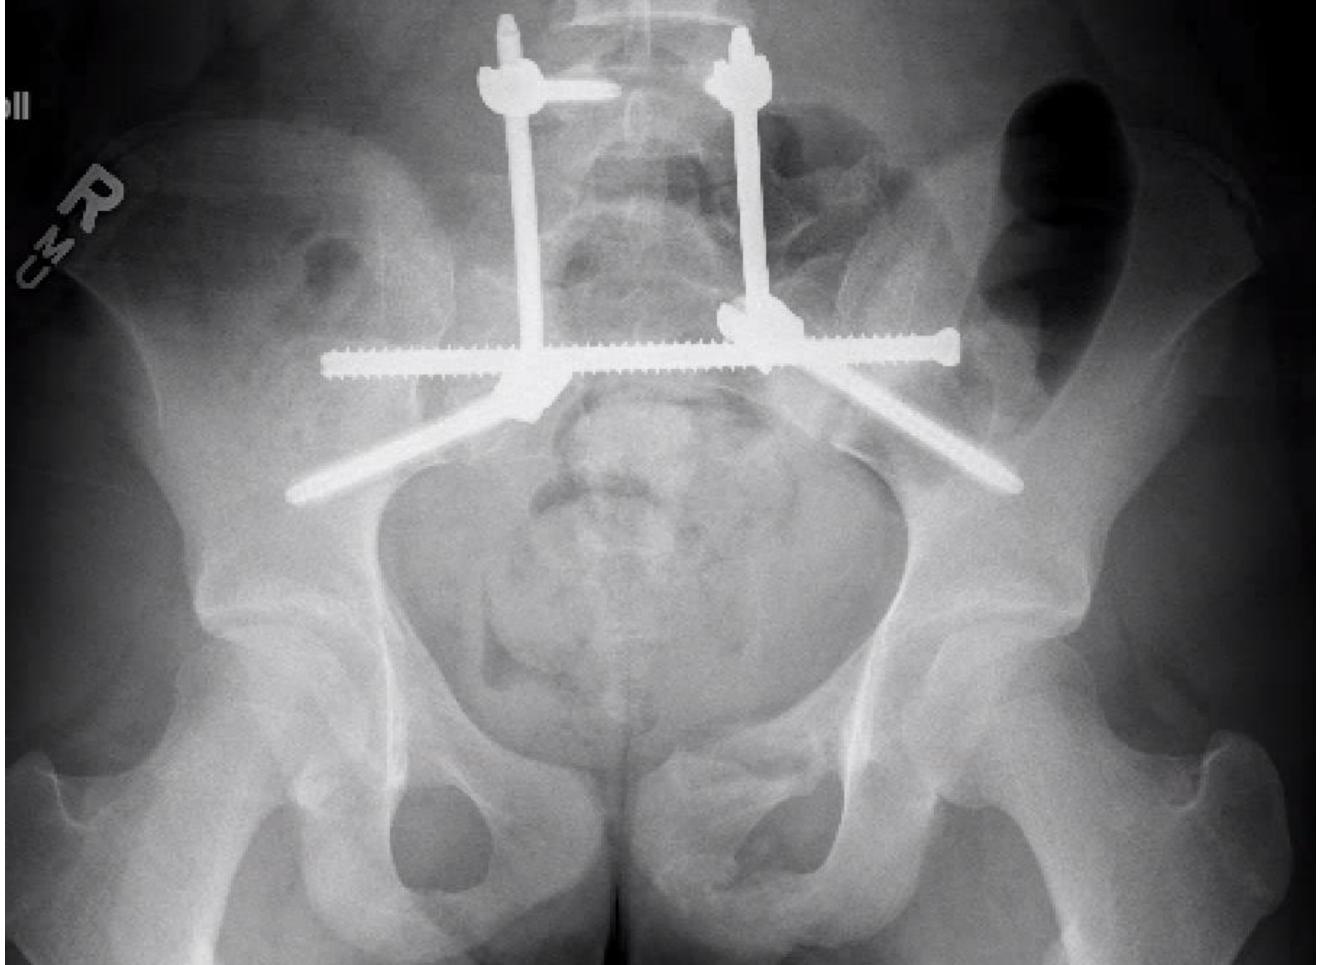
AP pelvis radiograph at four months post-operation demonstrating healing fractures with screws still fixed and in place. No further X-rays were warranted beyond this point, and hardware was removed at the 6-month post-operation mark.
